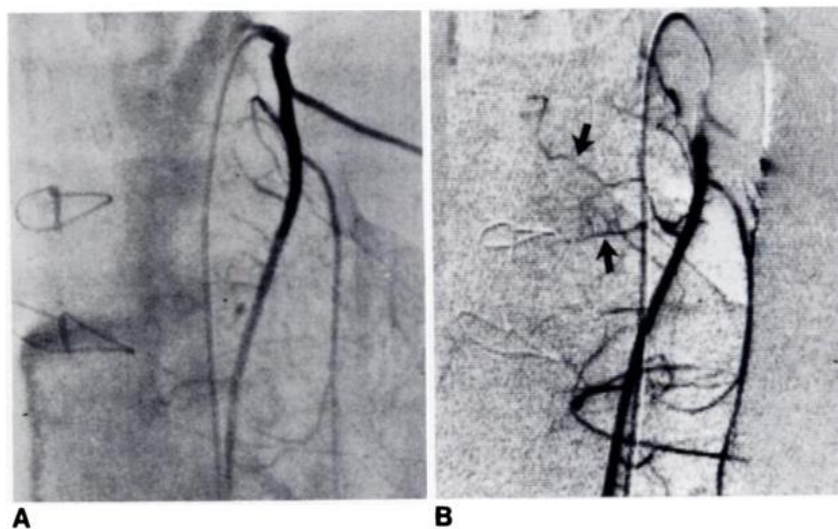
Comparison of conventional X-ray angiography and DSA⁴⁸. (A) Conventional X-ray angiography image (B) DSA image of the same vessel (black arrow indicates small vessel branches found in DSA)
